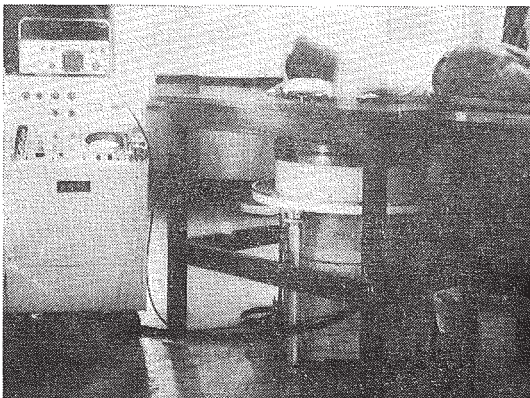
Arrangement of the ultrasonic apparatus.
